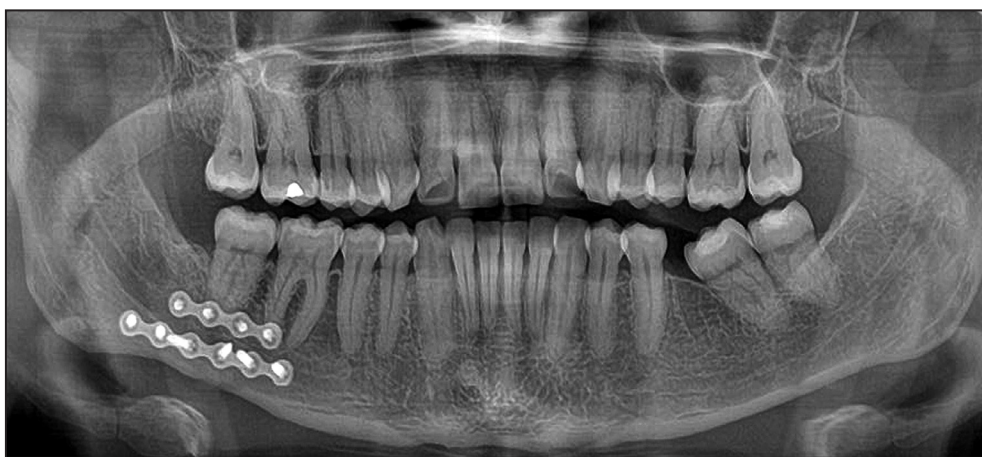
Postoperative panoramic radiograph after the fixation of the mandibular fracture registered within 1-year follow-up.
